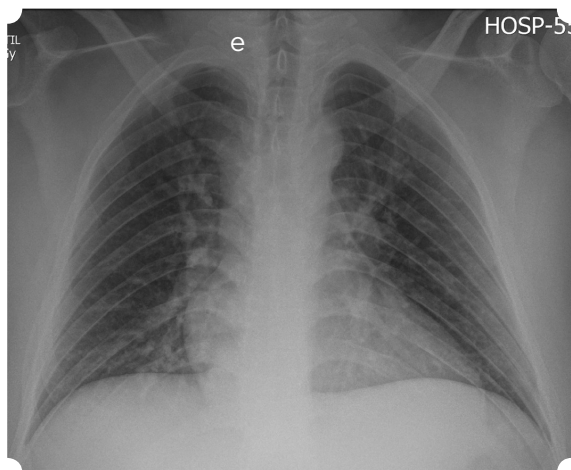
Chest X-ray control at 48 hours. Almost complete resolution of the alveolar opacities visualized in the initial study.
